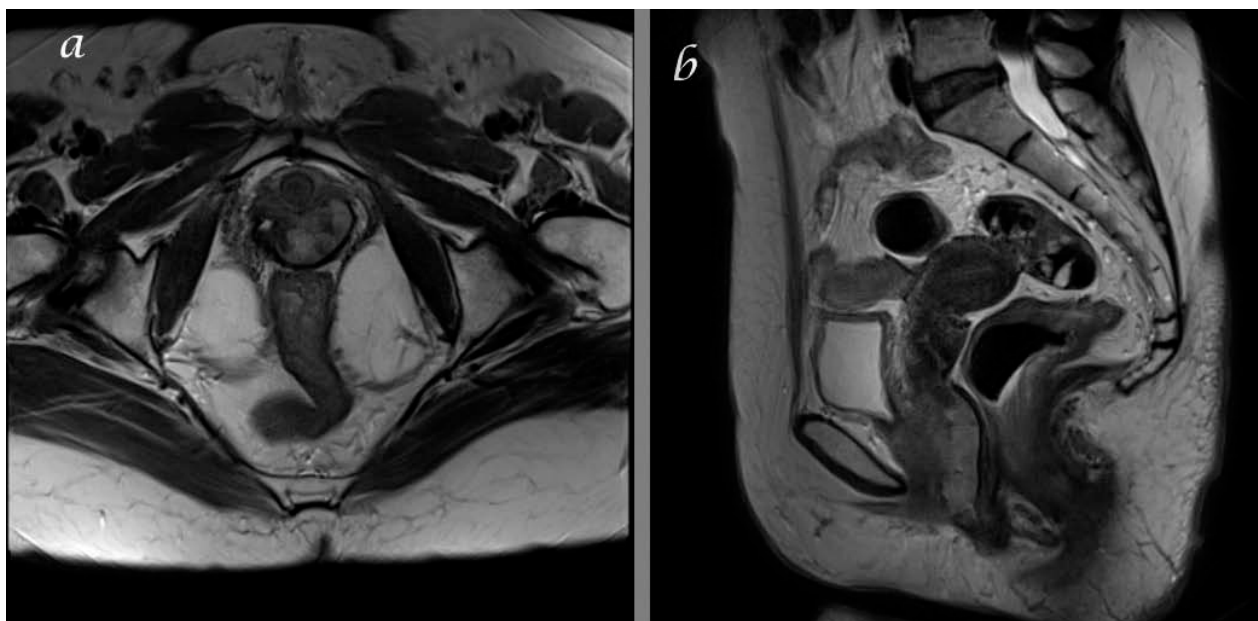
T2 weighted MR image in axial (a) and sagittal (b) views showing a well-circumscribed vaginal wall mass
